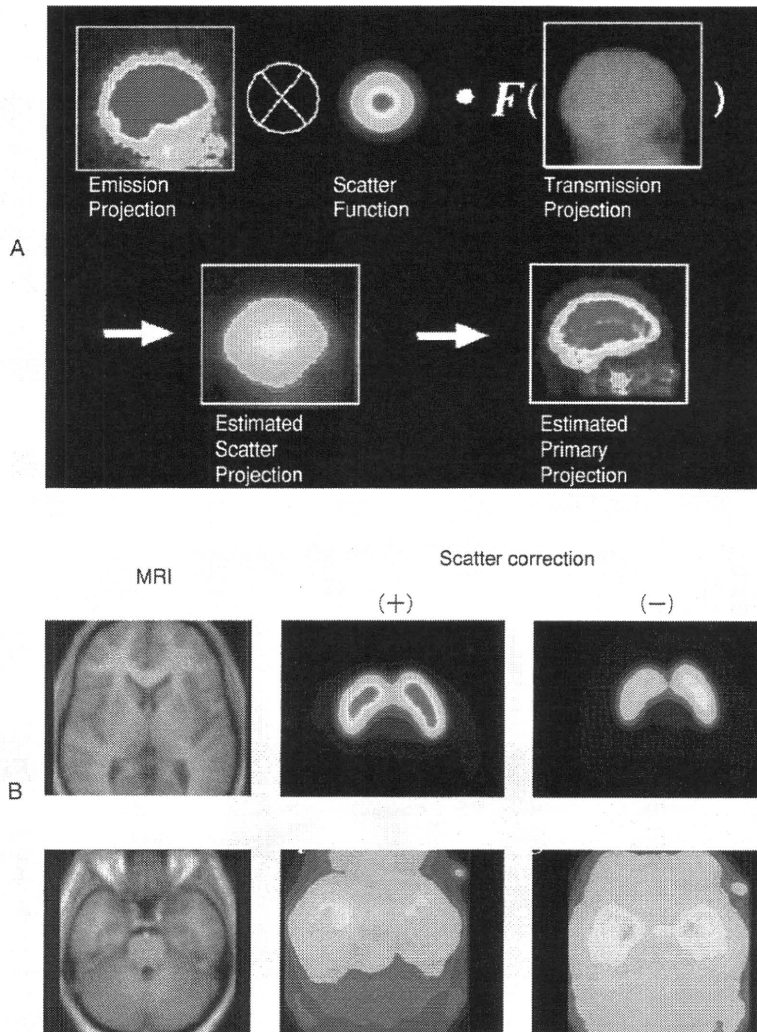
定量的 SPECT 画像再構成における散乱線補正の効果
